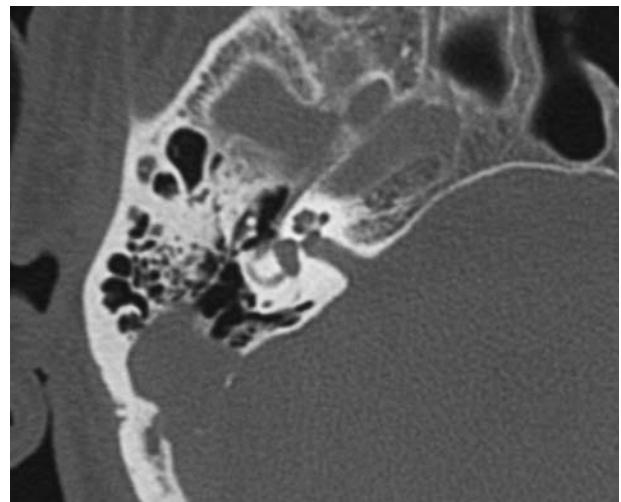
(Patient 2) CT scan shows lesion on right side confined to mastoid process. Attic and antrum are free of disease.
